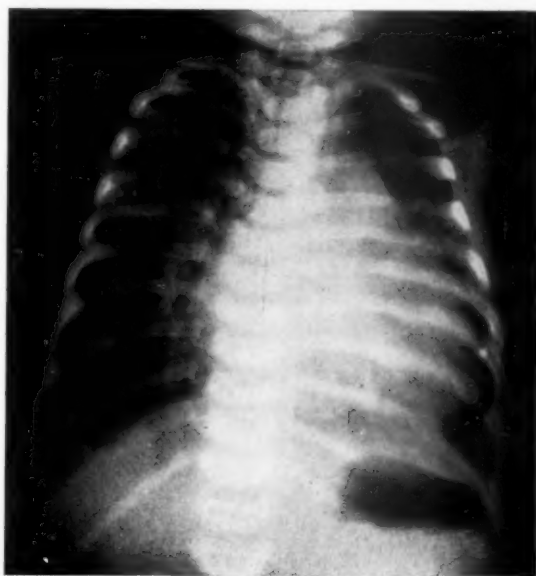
Roentgenogram of the thorax. Marked cardiac enlargement.
